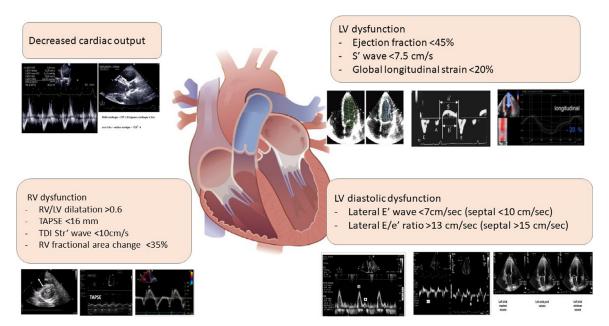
Echo parameters used to diagnose SCM. LV: Left ventricular; RV: Right ventricle; SCM: Septic cardiomyopathy; TDI: Tissue Doppler imaging; TAPSE: Tricuspid annular plane systolic excursion.
